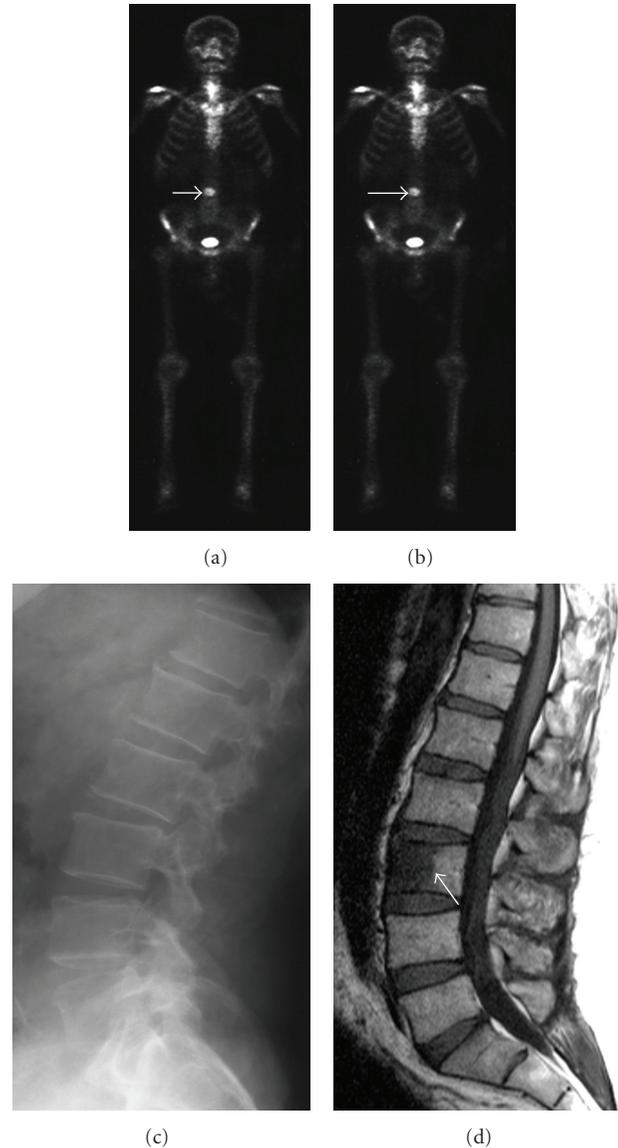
Example of a 55 years old patient diagnosed with high-risk localized disease. ^{99m}Tc bone scan shows an area of uptake in the body of the 3rd lumbar vertebra ((a) and (b)). Confirmatory X-ray is read as normal (c) although MRI of the axial skeleton (T1 sequence, (d)) shows a large focal area of malignant replacement of the bone marrow.
